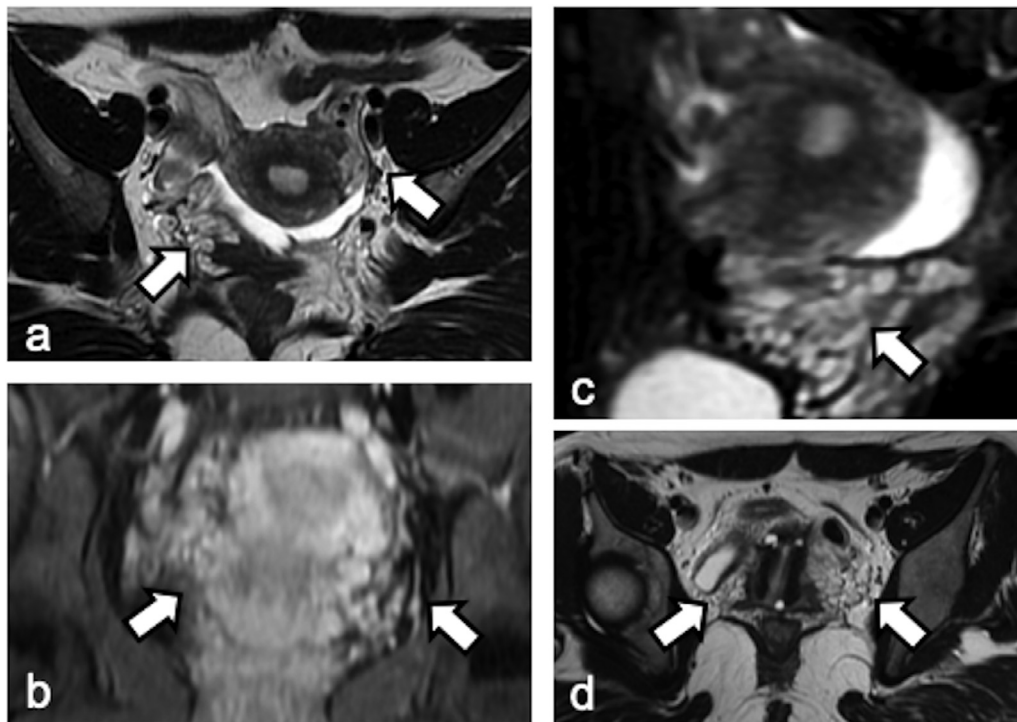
MRI imaging. Axial (a) and oblique (d) T2-weighted SSFSE, T1-weighted LAVA after contrast media administration (b) and T2 sagittal MRI (c) sequences showing pelvic venous congestion (arrows).
